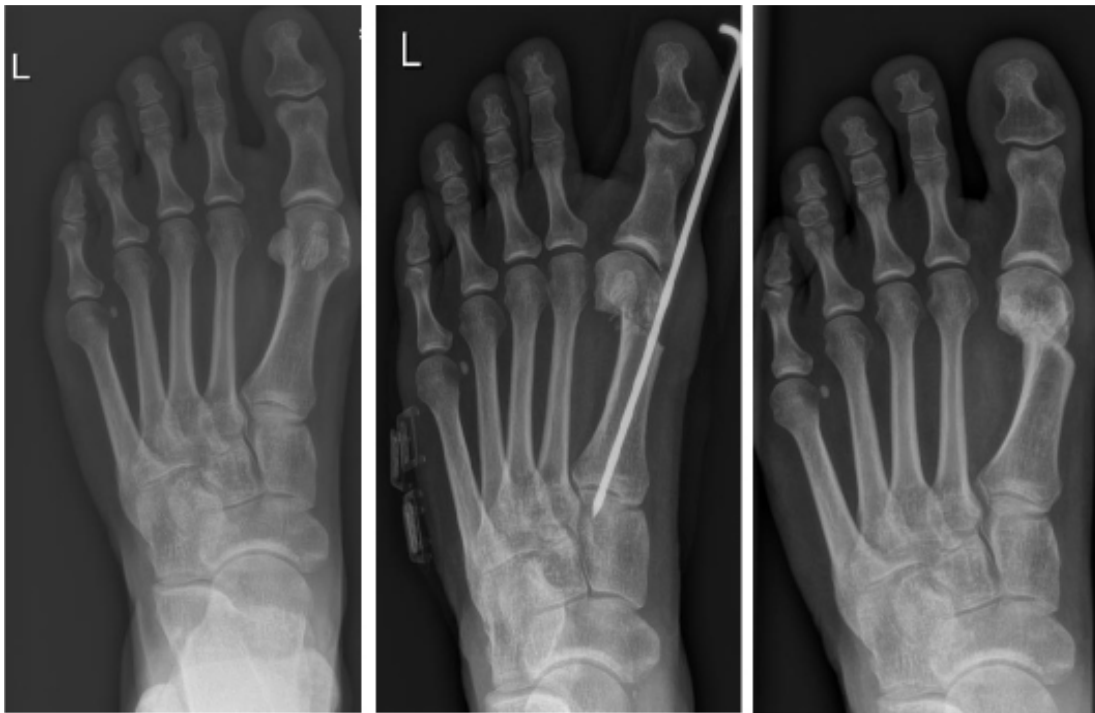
Full weight-bearing dorso-plantar x-rays taken preoperatively, and 6-week and long-term follow-up examinations
